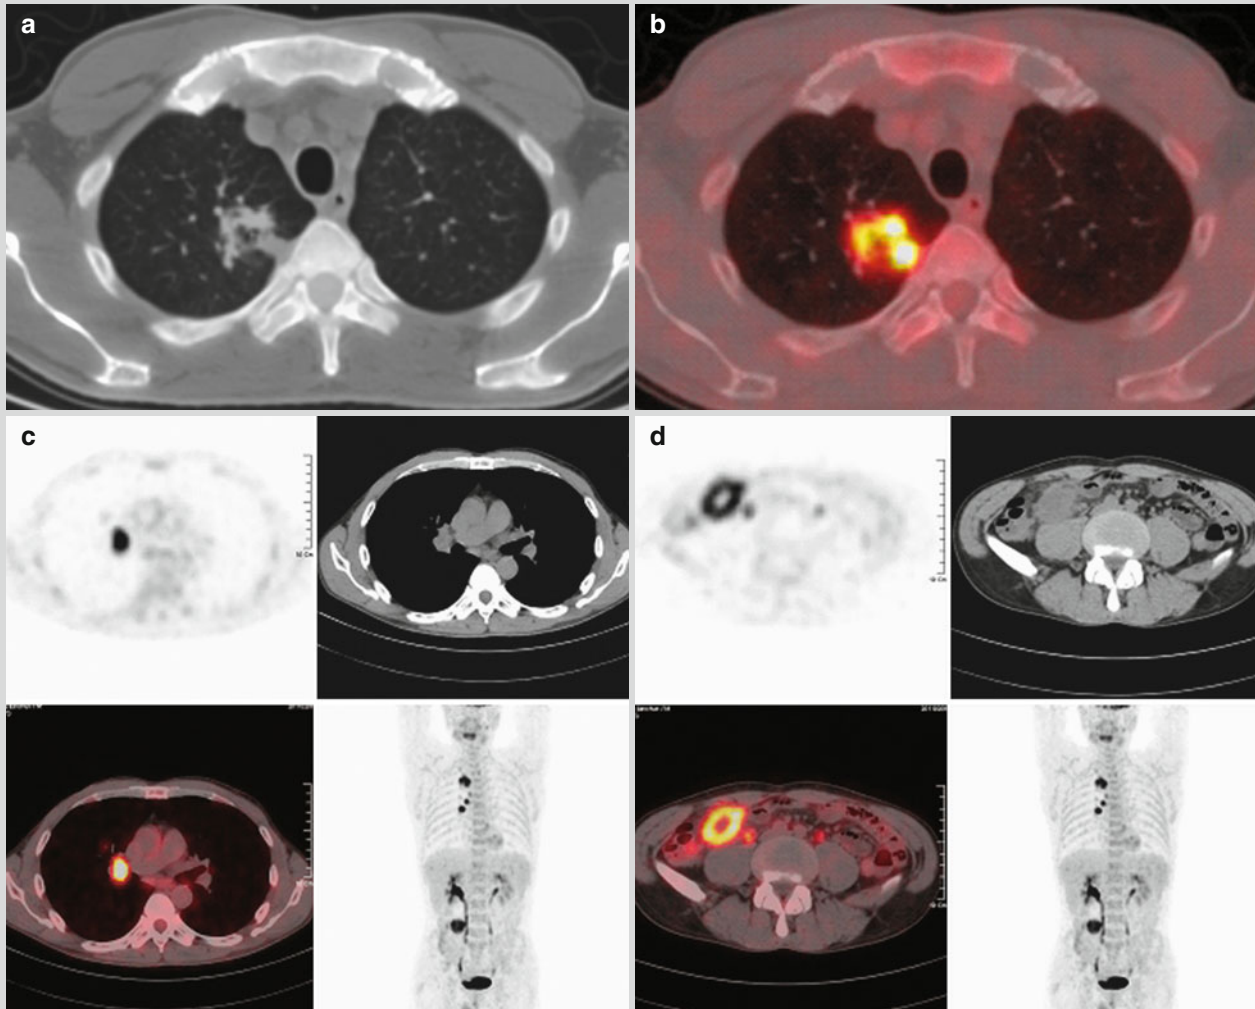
Pulmonary TB and abdominal TB. (a) CT scanning demonstrates irregular spots of shadows comprising a nodular lesion at the apical posterior segment of the right upper lung lobe, with lower density at the center. (b) PET/CT demonstrates increased HDG metabolism around the lesion, with SUVmax11.2 and defective metabolism of the central low-density area. (c) It is demonstrated
